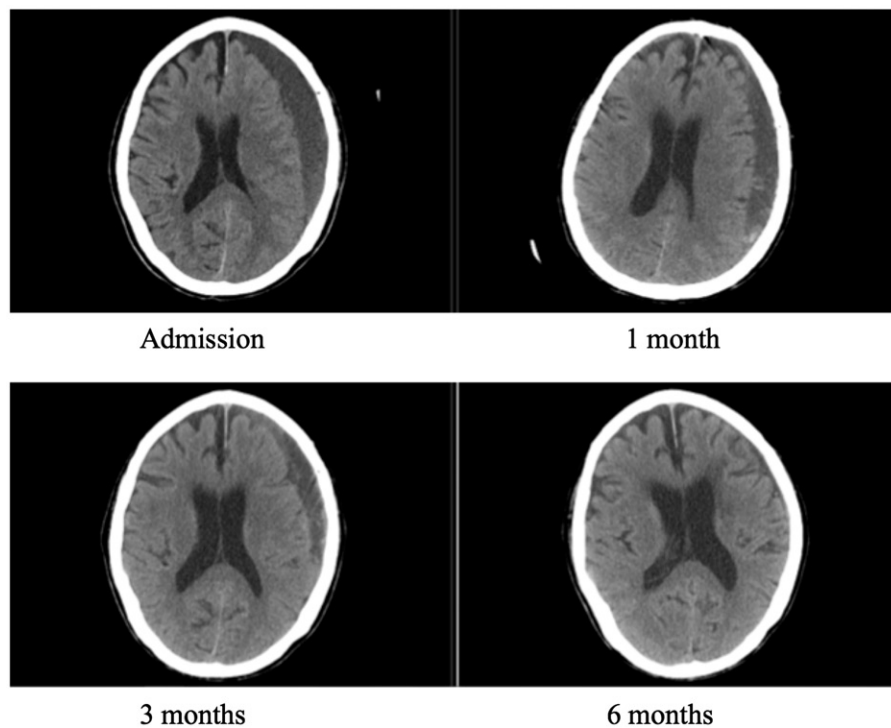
CT brain scan of a 75-year-old gentleman presented with unsteady gait.
